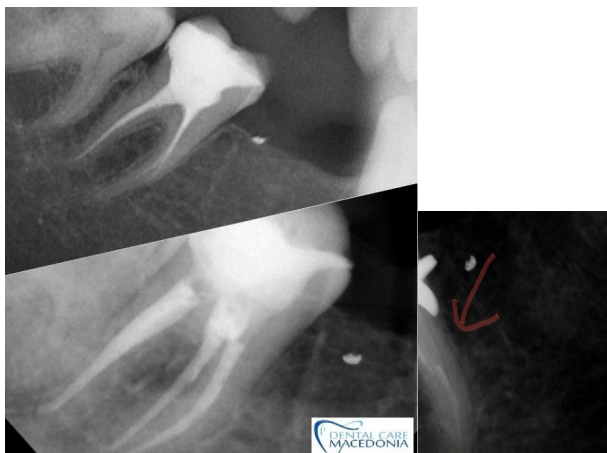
Radiographic view of tooth 46 before and after the final obturation.
